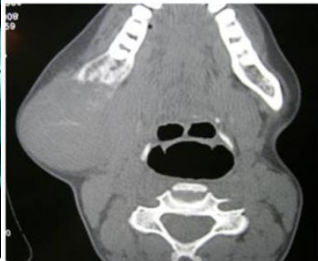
CT SCAN of the swelling .
